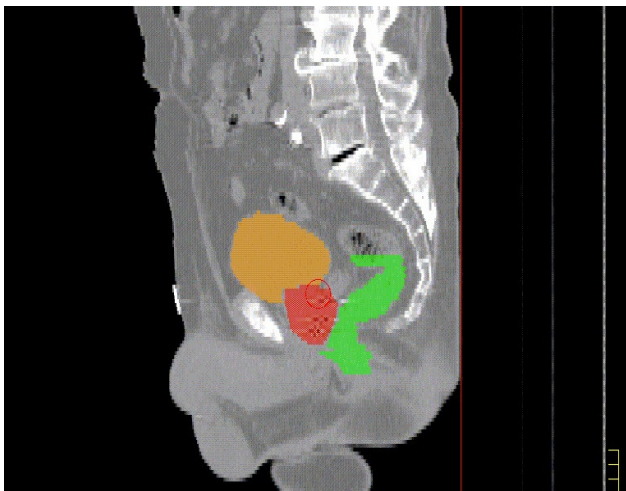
Sagittal section of a contoured, male CT image. The red area represents the prostate gland, the green area corresponds to the rectum, and the orange area is the bladder.
